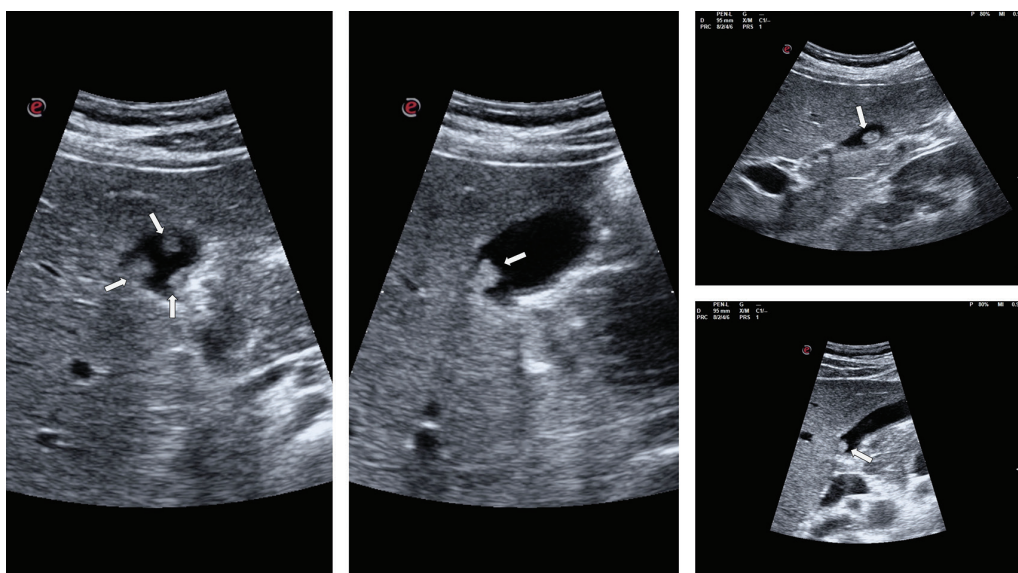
Ultrasound images of gallbladder polyps. These images show polyps in the lumen of the gallbladder in different lead-exposed workers (arrows)
